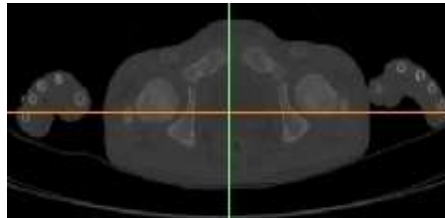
CT image of normal individual
